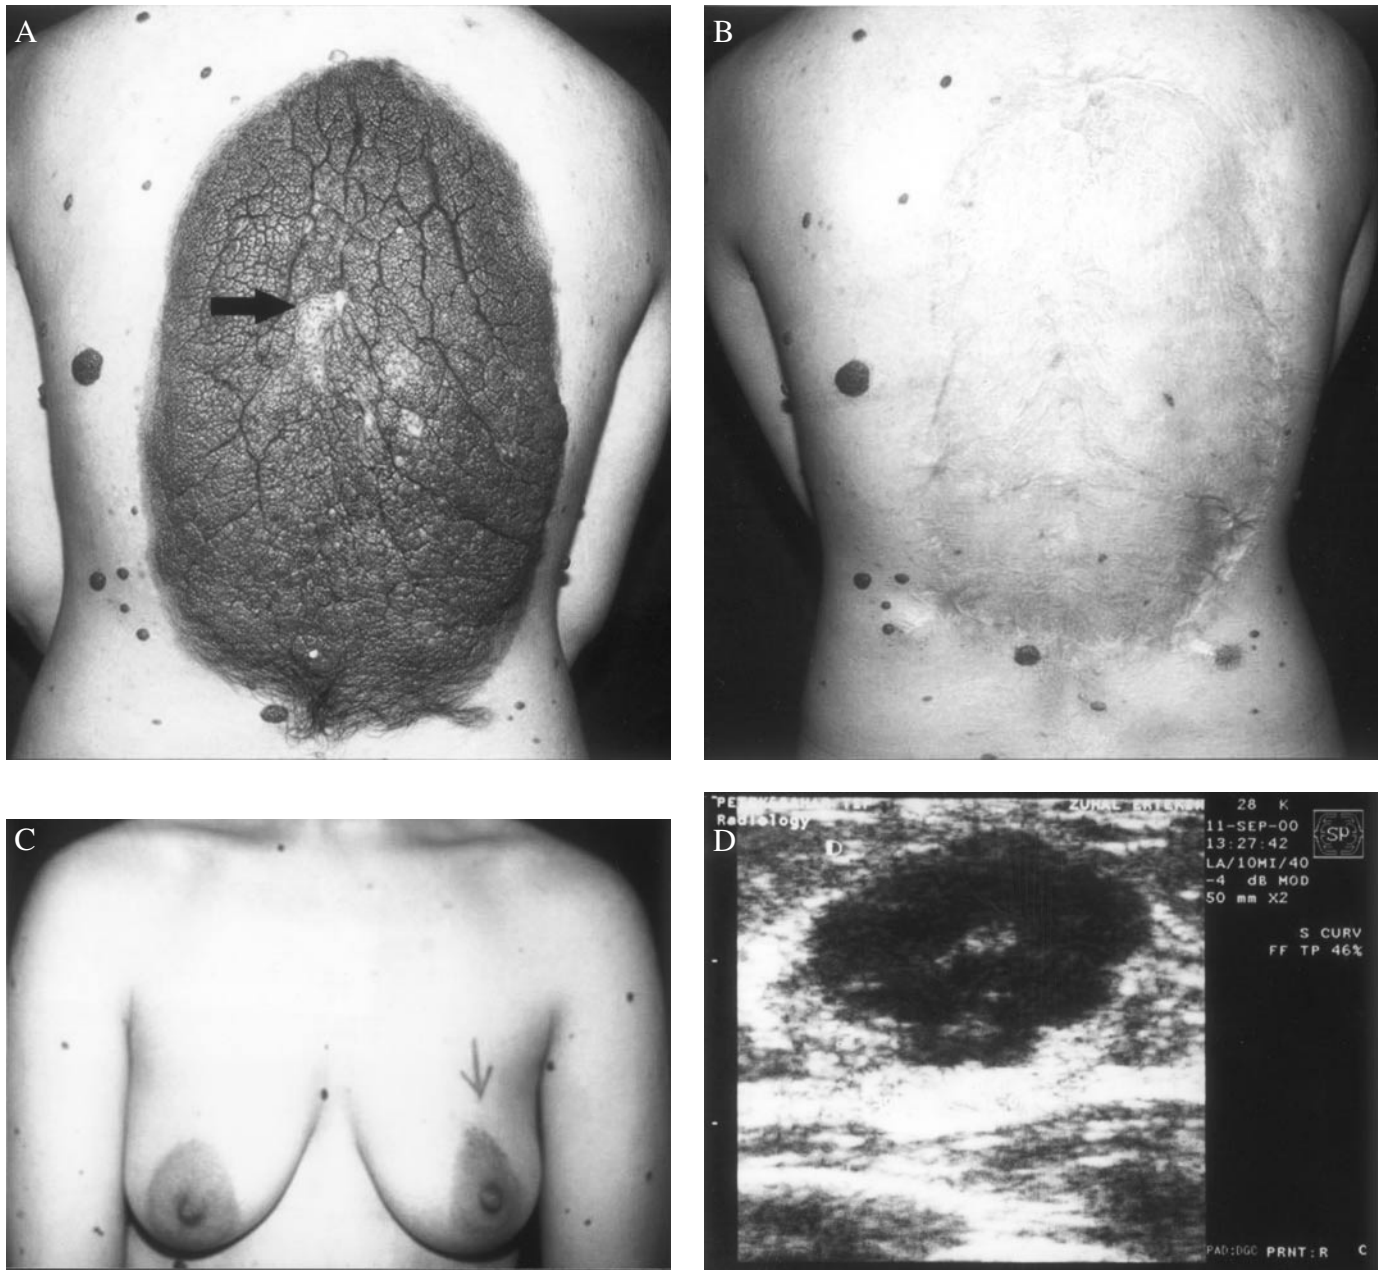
A 23-year-old woman (case 11) with malignant melanoma originated from giant congenital compound nevus. (A) The arrow indicates a previous biopsy site. (B) WLE and skin graft reconstruction was done. (C) 27 months after definitive surgery, a palpable breast mass (2×2 cm in diameter) was found on clinical examination (arrow indicates the breast mass). (D) Breast ultrasonography showed a single cystic lesion (13×11 cm in size) with contour lobulation and internal septations. Fine-needle aspiration biopsy revealed metastatic CMM and metastasectomy was performed.
